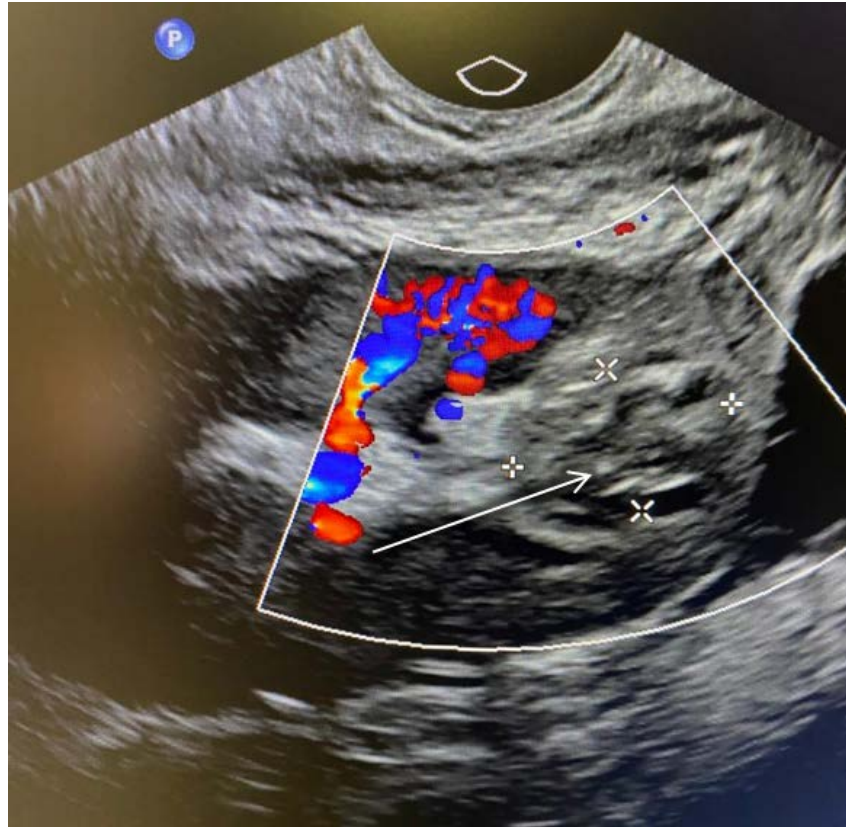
The renal graft image at Doppler ultrasonography. No contrast enhancement of the false aneurysm sac after embolization (the arrow indicates the thrombosed false aneurysm sac)
